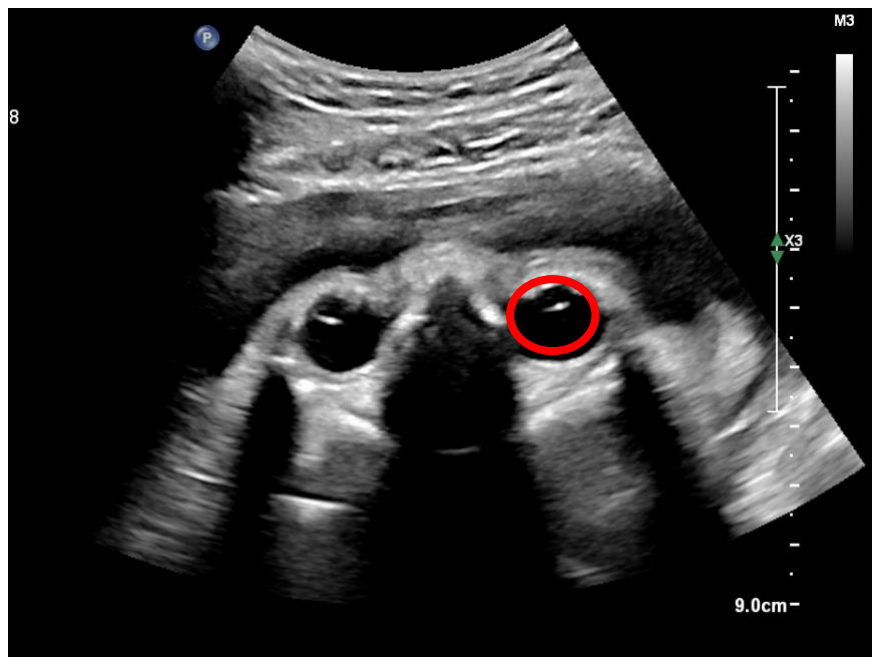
An image of a 2D ultrasound of a fetal head in the transverse plane.
